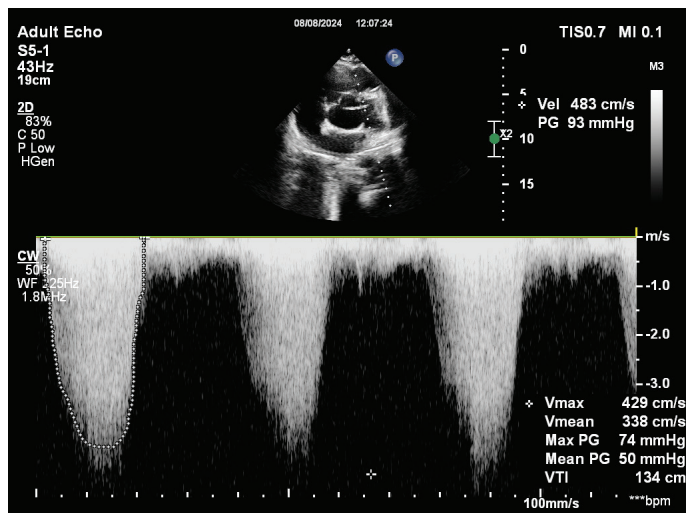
Echocardiography showing a 2.0 cm ventricular septal defect (VSD) located in the subaortic region.
